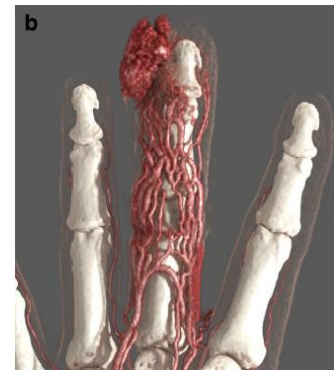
Dynamic CTA of a hemangioma [23]
